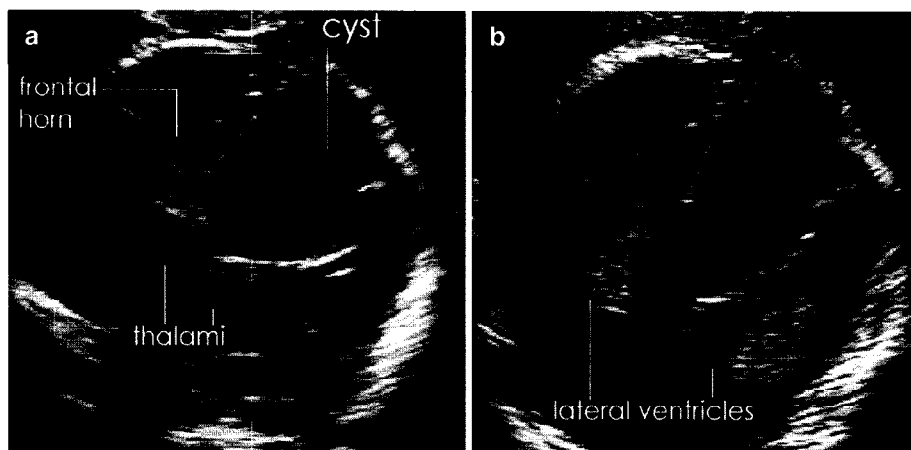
Case 3: anterior (a) and posterior (b) coronal scans obtained by transvaginal sonography, demonstrating a large arachnoid cyst of the midline. The cyst caused lateral dislocation of the cerebral hemispheres and was in continuity inferiorly with the third ventricle. The corpus callosum was obviously absent
